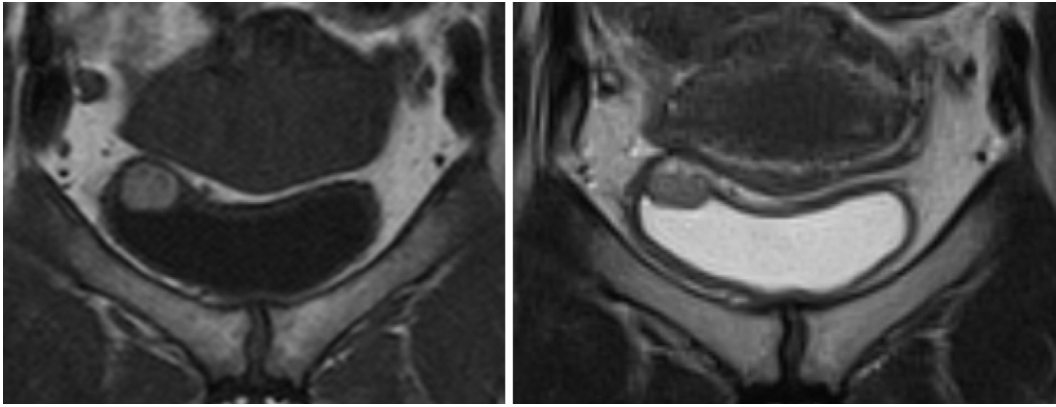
Magnetic resonance imaging in the coronal section revealed a mass in the urinary bladder, just as with abdominal echo and computed tomography (CT) (left panel: T1-weighted imaging, right panel: T2-weighted imaging).
